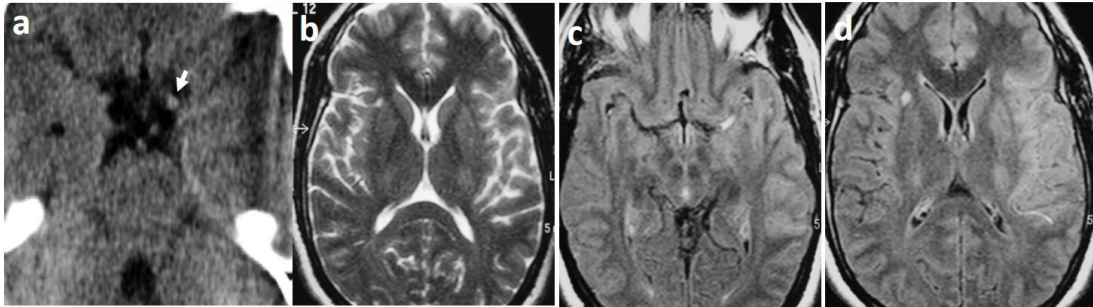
[a-d] (a) Axial NCCT brain shows hyper dense left MCA sign (white arrow). (b): Axial T2WI shows no definite brain signal abnormalities in Lt. Hemisphere. (c&d) FLAIR MRI show hyper intense Lt. MCA sign with effacement of cortical sulci and faint hyper intense area in the Lt. temporo-parietal region in a case with Rt. sided hemiplegia of 5-hours duration.
